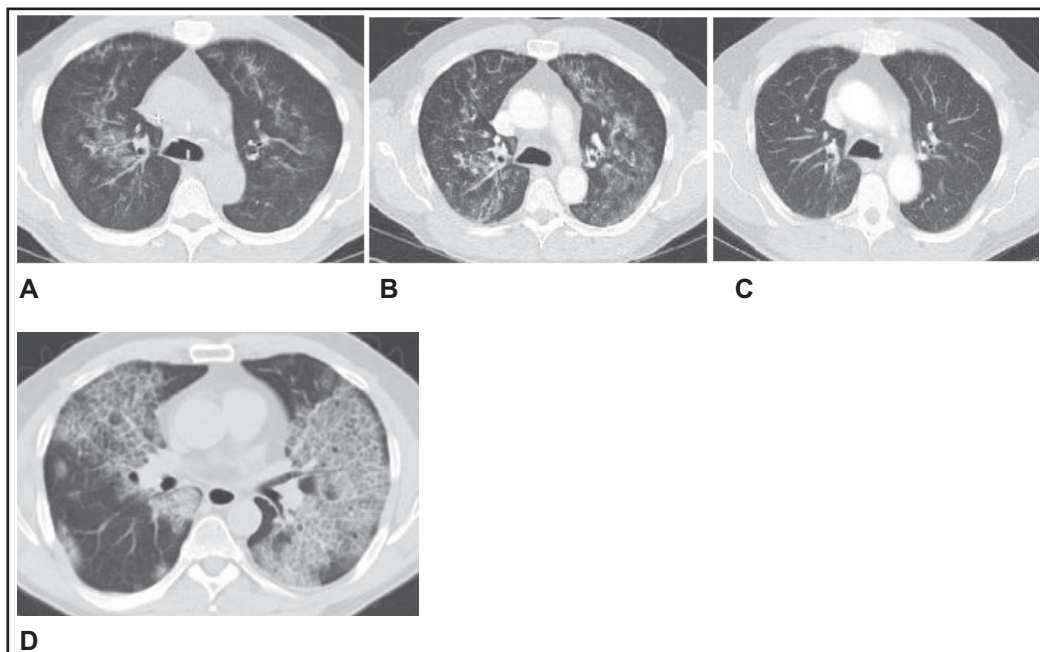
A. Thoracic CT scan at presentation showing ground-glass opacities reported as multifocal pneumonia. B. Thoracic CT scan after 2 cycles of bendamustine and rituximab showing interval worsening of pulmonary parenchymal disease with increasing linear and ground-glass densities throughout both lungs. C. Thoracic CT scan 6 months post-bendamustine and rituximab showing generalized improvement in the pulmonary densities. D. Thoracic CT scan of a different patient with idiopathic (autoimmune) PAP showing bilateral geographic ground-glass opacities (GGO) with inter-lobular septal thickening, creating a characteristic mosaic or so called "crazy paving pattern" in both lung fields.
